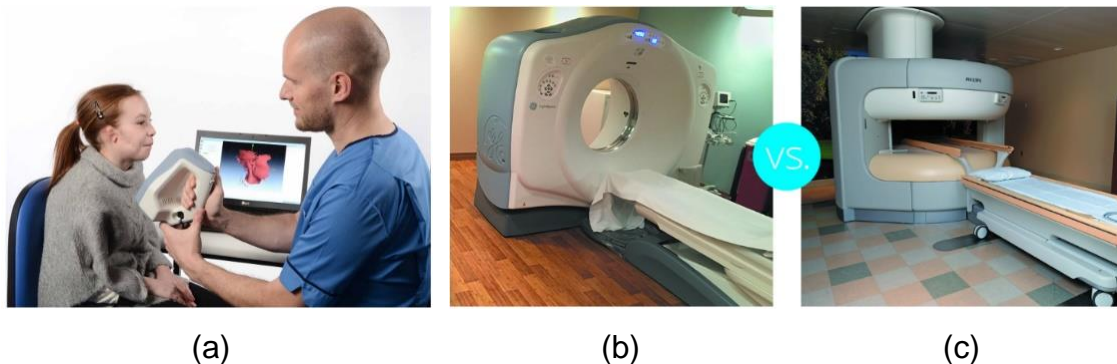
(a) 3D scanning [45]. (b) CT scanner vs (c) MRI [46].
